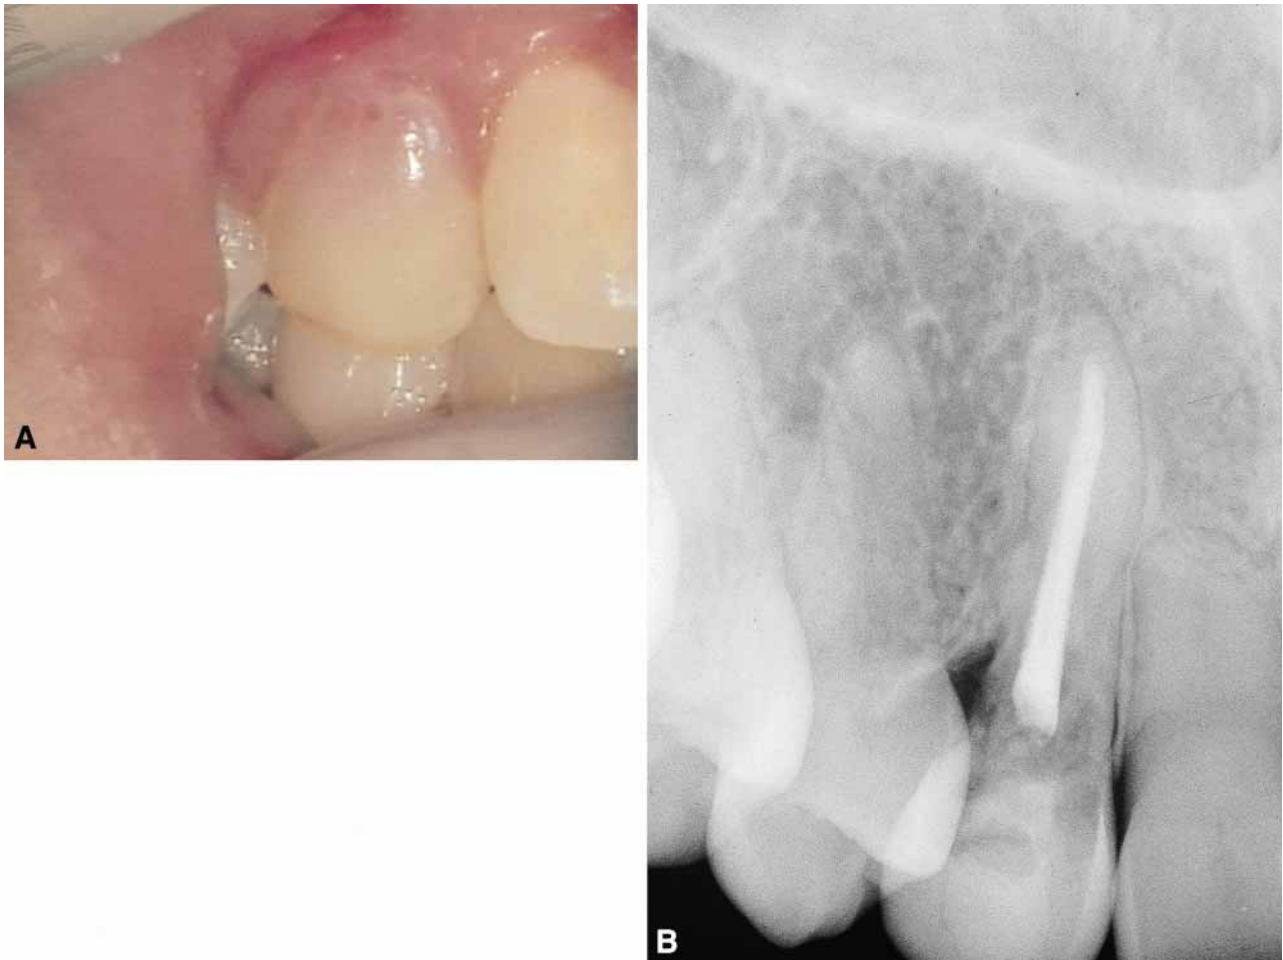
A. "Pink spot" of external root resorption. The granulosomatous tissue has spread coronally and undermined the enamel, resulting in the pink colour seen in the crown. B. Radiographic appearance of tooth showing external root resorption with a root-treated tooth. The tooth had been root-treated 3 years previously before signs of resorption were present. Therefore, the lesion cannot be internal root resorption.
